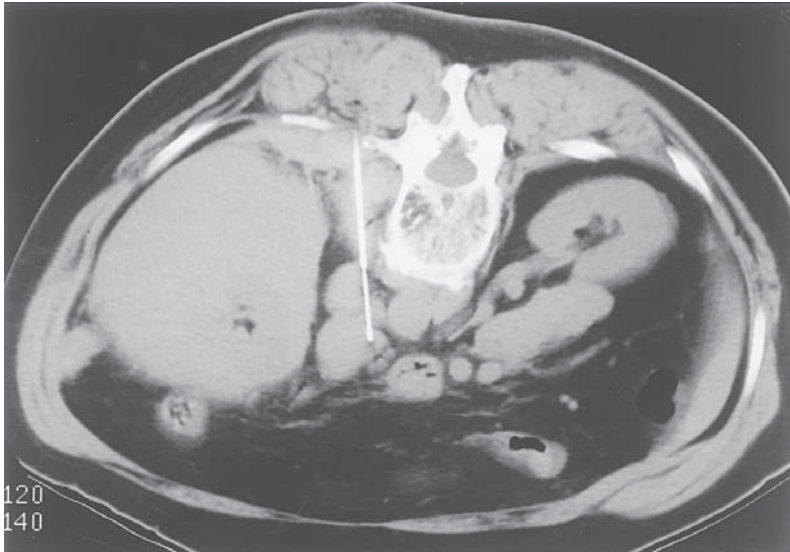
CT scan of an infiltrative process involving the left kidney in a patient with enlarged para-aortic lymph nodes. Biopsy of a lymph node (shown) and renal mass both revealed malignant lymphoma.
